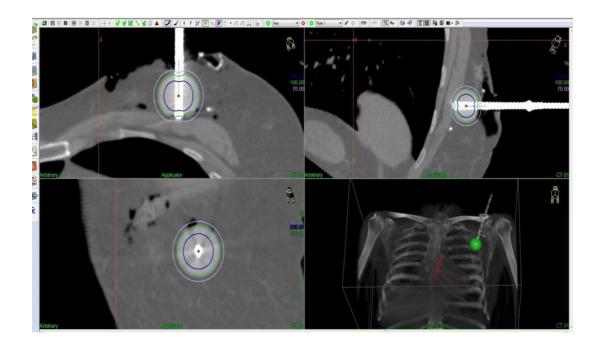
CT scan shows the location of the applicator.
